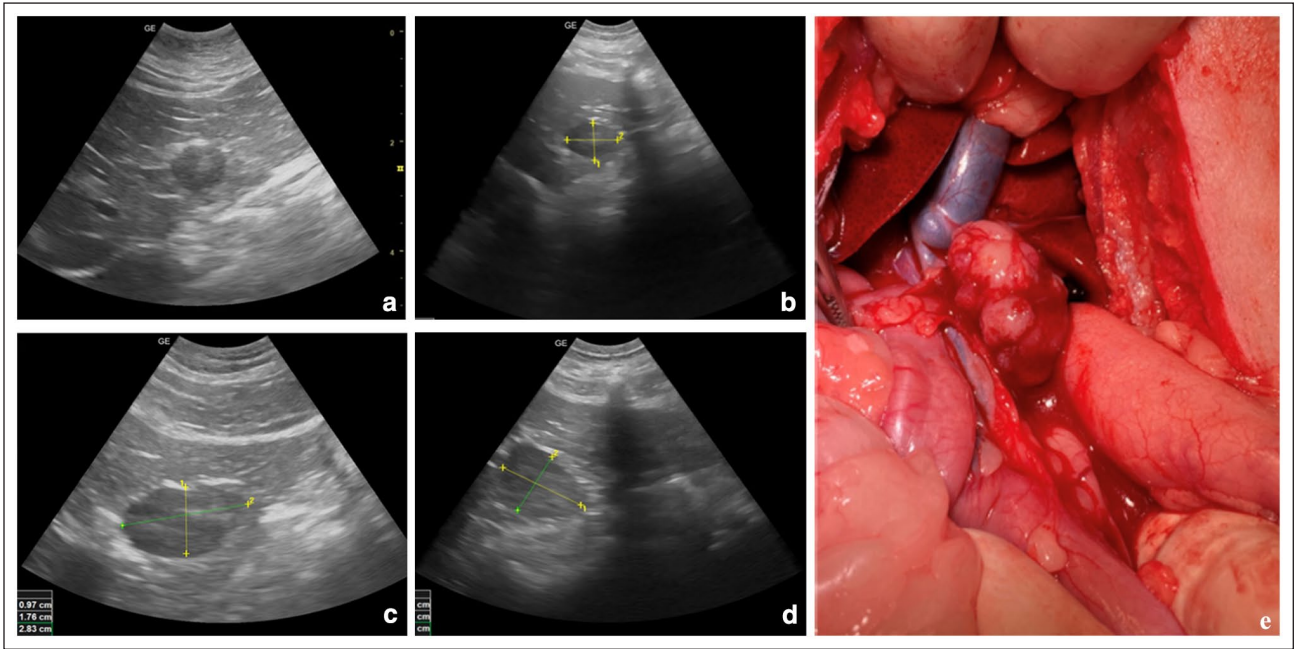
Sequential changes in ultrasound-acquired liver nodule size and view of the liver nodule at surgery: (a) nodule size at time 0: 0.99×0.70 cm; (b) nodule size after 2 months: 0.99×1.33 cm; (c) nodule size after 3 months: 0.97×1.76 cm; (d) nodule size after 4 months 1.73×1.34 cm; and (e) multilobulated discoloured liver mass protruding on the liver surface
